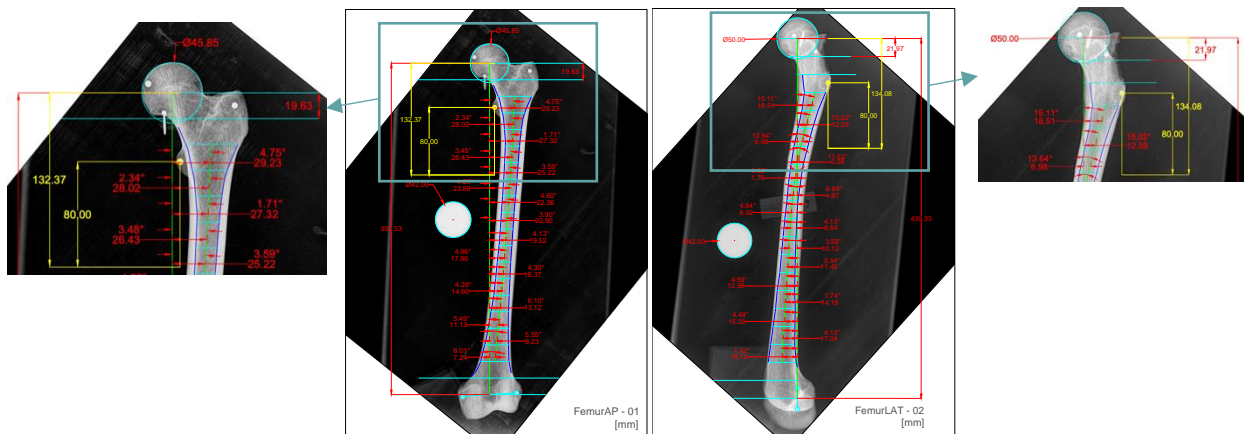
Completely measured LAT view and AP view of the x-ray no-02
